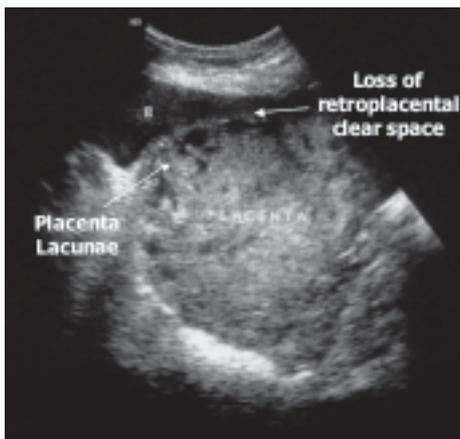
Ultrasound features of placenta accreta.
